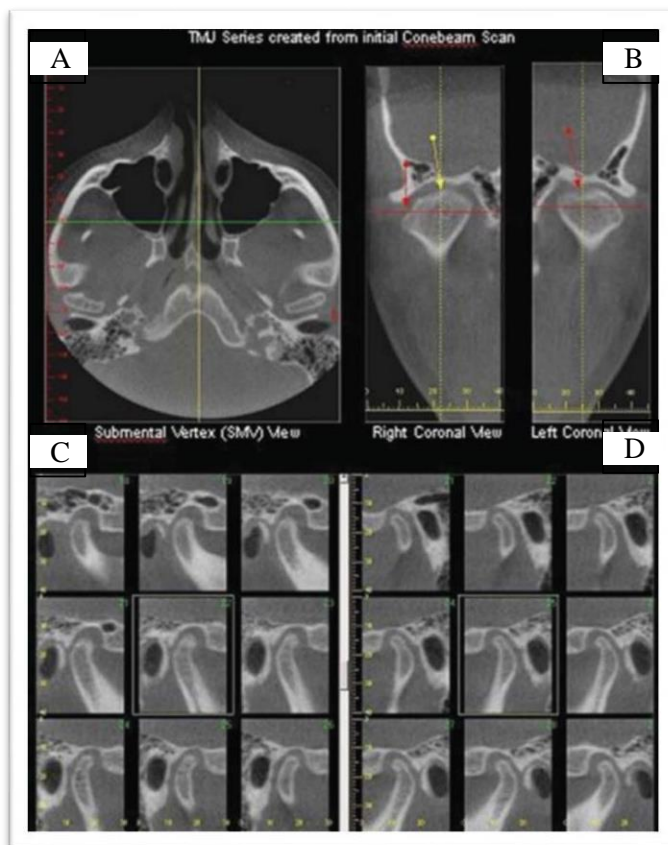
Different sections of CBCT depicting TMJ. A). Axial section at the level of the condyle showing degenerative changes particularly on the right condyle. B). Coronal section of CBCT. C). Sagittal section of the right condyle showing cystic changes. D). Sagittal section of the left condyle. Images adapted from Harrell. (114)
